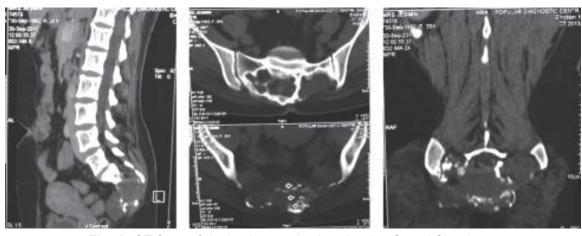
CT Scan of the lumbosacral spine showing Sacral Chordoma.
